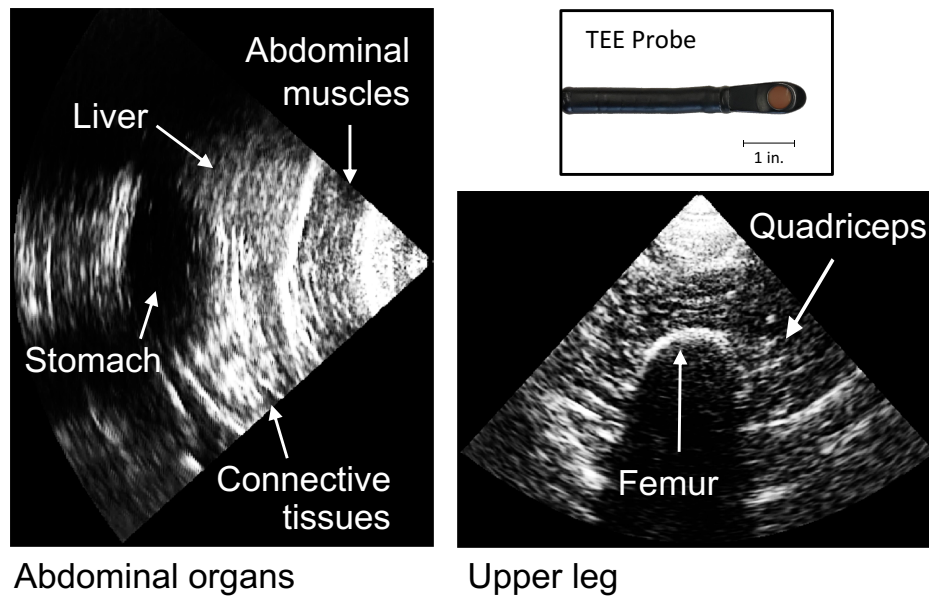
Ultrasound images of the femur and the stomach were acquired using a TEE probe. The tip of the TEE probe is shown at the top.*
